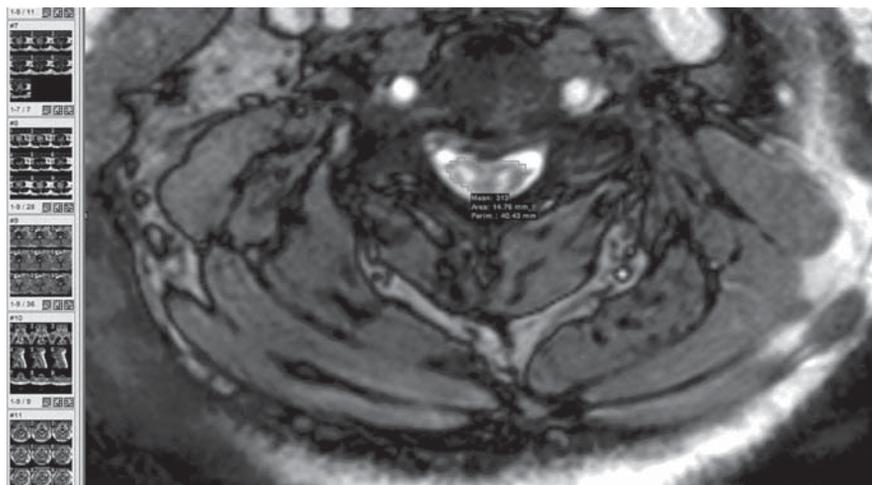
Measurements for the TA of the spinal cord using T2-weighted axial MR image with a digitizer linked to a computer (Issa Network station 3.1). TA indicates transverse area; MR, magnetic resonance.
